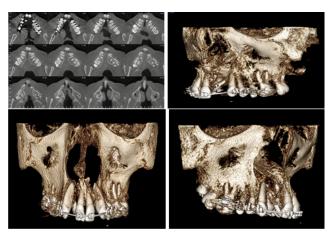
Postlevelling & alignment CBCT images
